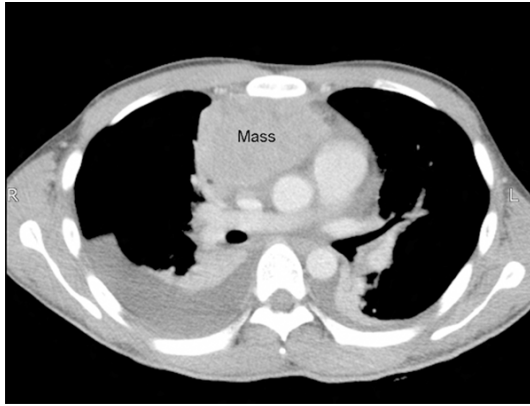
CT scan of mediastinal structure. Contrast enhanced chest CT (mediastinal windows) at the level of the right pulmonary artery showed homogeneous medium degree enhancement of the mass. There was obvious compression and distortion of mediastinal structure and bilateral pleural fluid.
